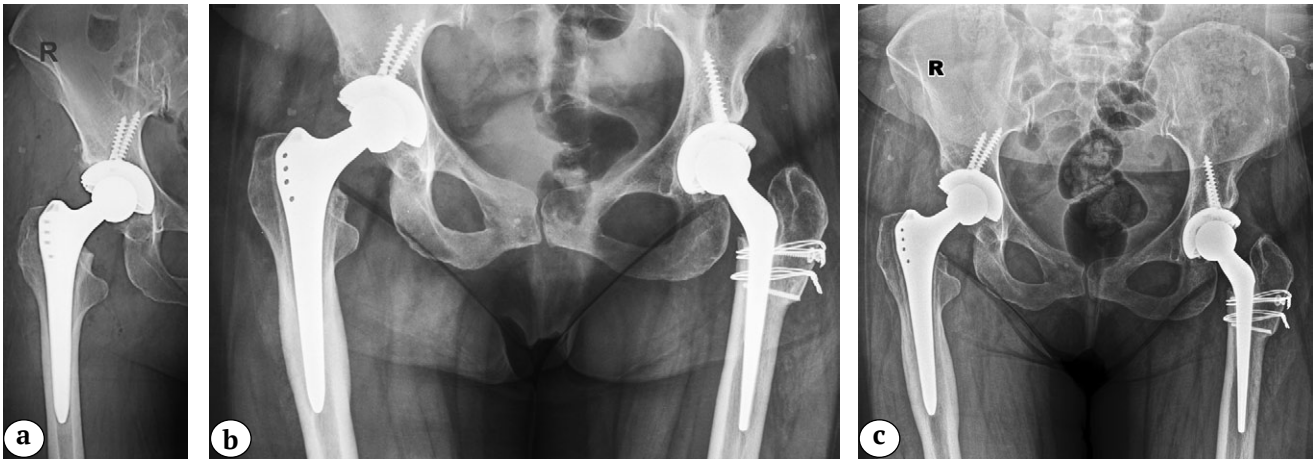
A 49-year-old patient: bilateral hip dysplasia with high dislocation of the left hip (C2 according to Hartofilakidis) and low dislocation of the right hip (B2 according to Hartofilakidis). In June 2011, left THA was performed with a shortening osteotomy according to Paavilainen. In March 2012, right THA was performed (a). On follow-up X-rays in February 2014, radiolucent lines are already detected in zones 1, 2, 6, and 7 of Gruen (b). However, until the beginning of 2020, there were no clinical manifestations of femoral component loosening. On X-rays in September 2020, the radiolucent lines became more pronounced (c), and the patient complained of hip pain after loading. Revision of the femoral component was performed (d)
